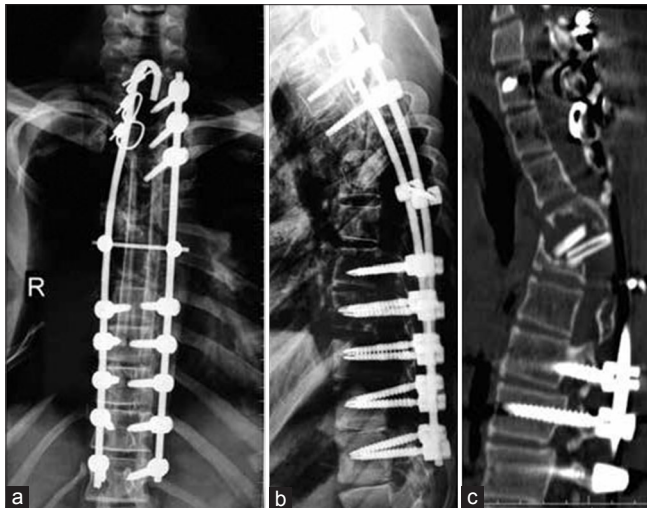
(a and b) Radiographs of dorsal spine anteroposterior and lateral views at 1 year followup showing maintenance of alignment; however, anterior fusion is not seen. (c) Computed tomography scan at one year showing anterior void and fibulae had not united
